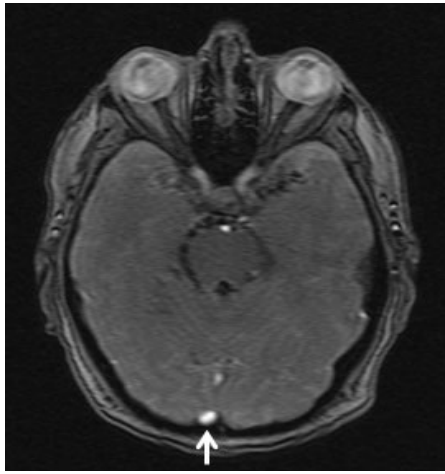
Brain MRI from 7/1/16 showing a focal infarction to the tip of the right occipital lobe
